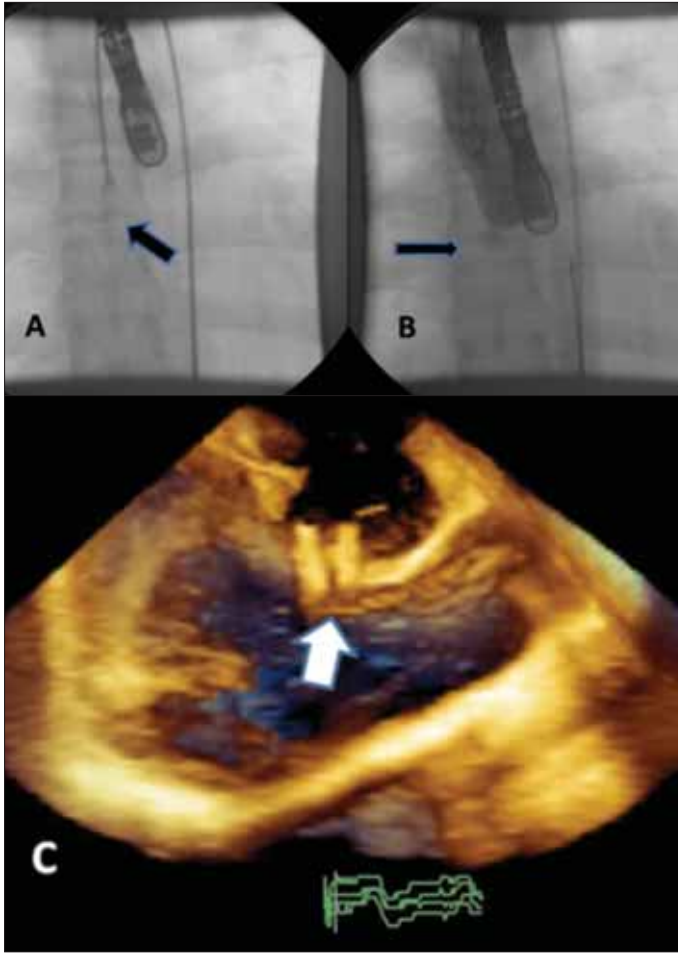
(A) An X-ray view of the Amplatzer device (arrow) after opening both atrial and aortic disks just before releasing with retrograde approach. (B) Aortography view showing complete closure of ruptured sinus Valsalva with no regurgitation. (C) 3D transesophageal echocardiography view depicting the closure of the ruptured sinus Valsalva with double disk Amplatzer device (arrow)
